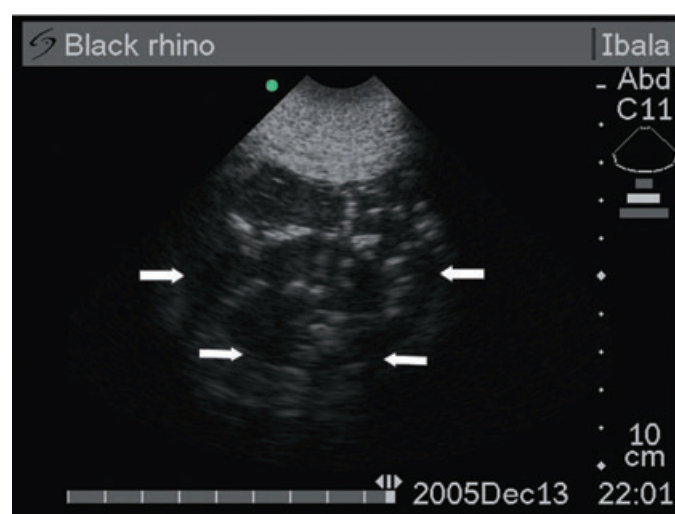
Ultrasonographic appearance of the seminoma in the 12-year-old male southern black rhinoceros. Arrows delineate the margins of the tumour.
